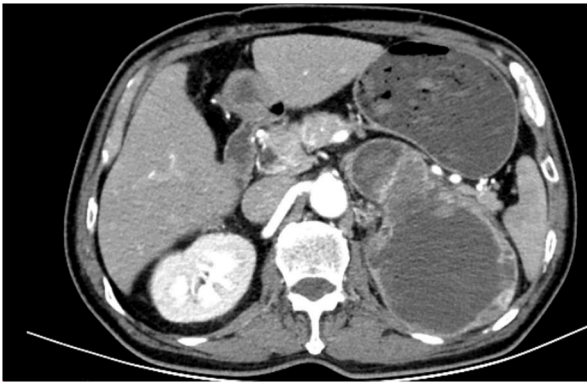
Computed tomography shows Cystic changes in the left superior pole.
